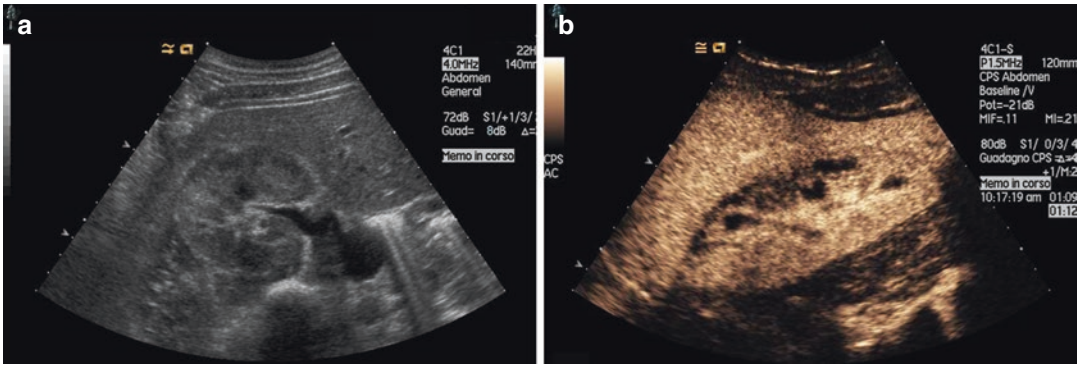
Renal infarction diagnosis by ultrasound. (a) B-mode transversal scan: the right kidney appears slightly enlarged with hypoechoic areas and poor
